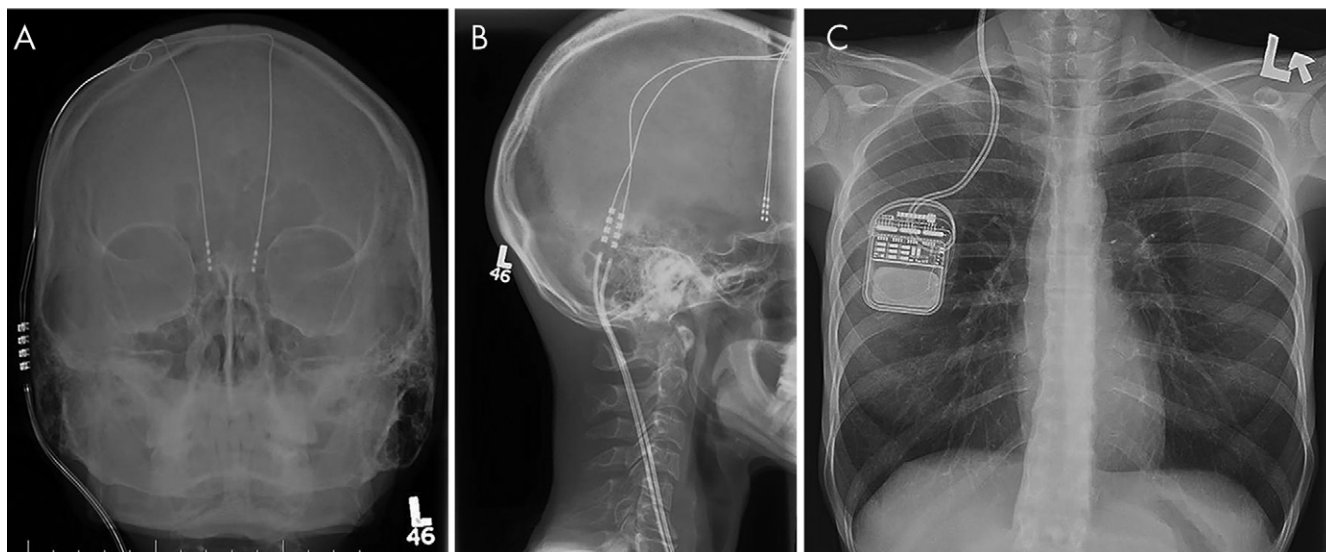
Radiographs of deep brain stimulation (DBS) device. Typical DBS hardware configurations used at our institution are seen on radiographs of, *A*, skull, *B*, neck, and, *C*, chest. Cranial loops of coiled extension wire have a diameter of approximately 2 cm. The remaining excess extension wire is coiled behind the thoracic implantable pulse generator.
